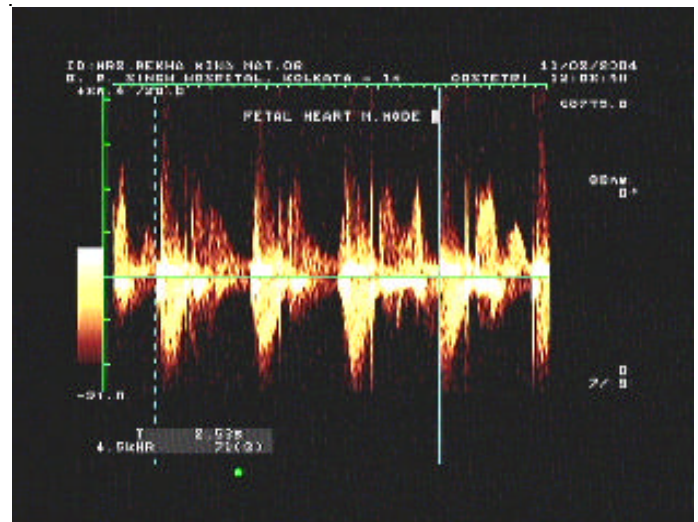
Doppler showing fetal bradycardia.
